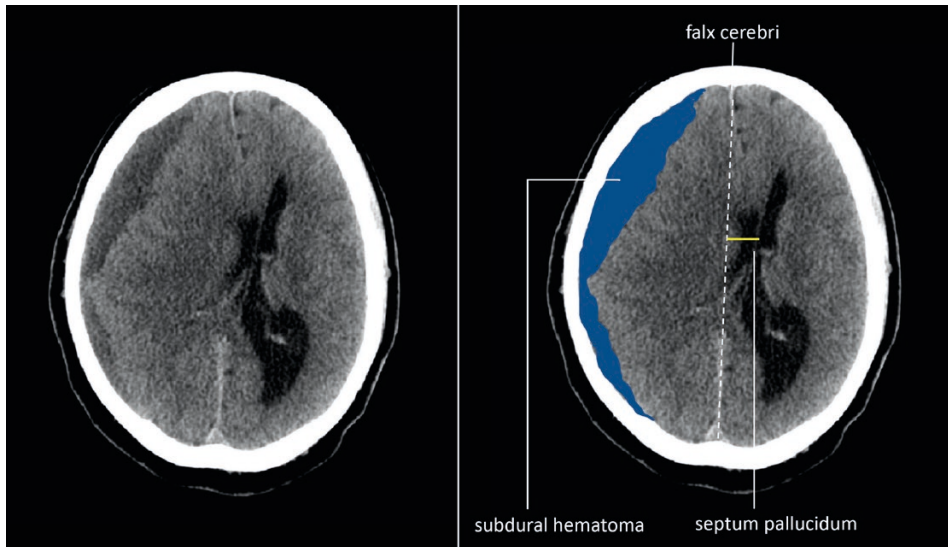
Patient A - CT scan of chronic subdural hematoma at presentation
